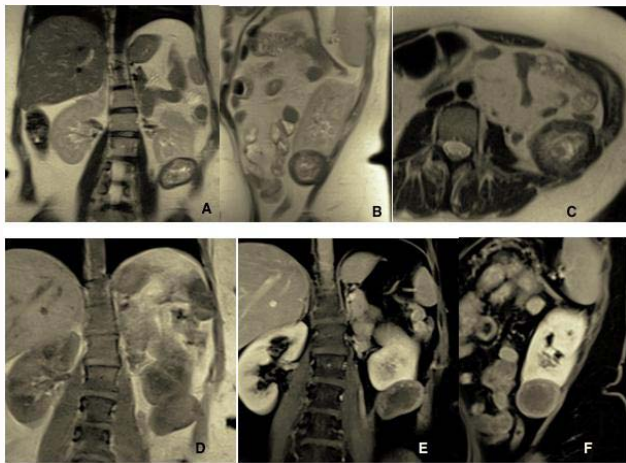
MRI images of T2A coronal (A), T2A sagittal (B), T2A axial (C), T1A coronal (D), after IVC M T1A coronal (E) and T1A sagittal (F).
